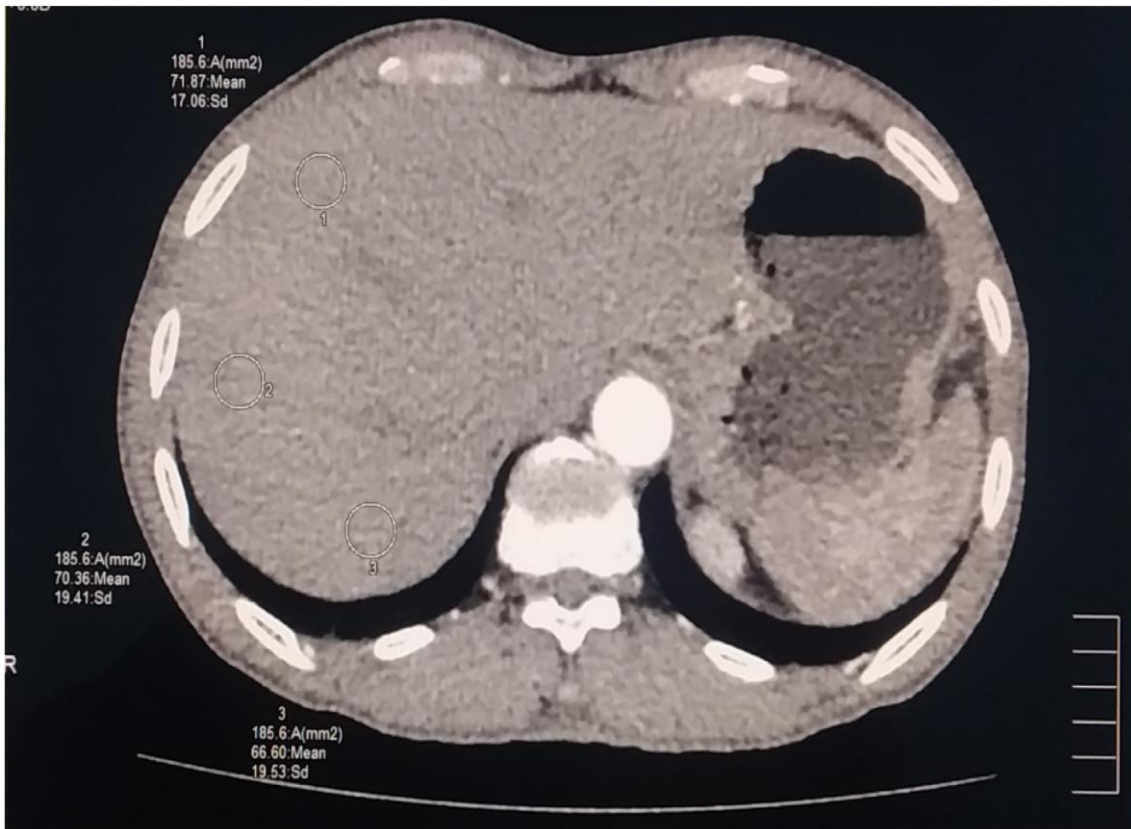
Measurements of noise in CT image for liver during low dose imaging protocols (120 kVp, 40 mAs, rotation time 0.5 s and helical pitch 65).
